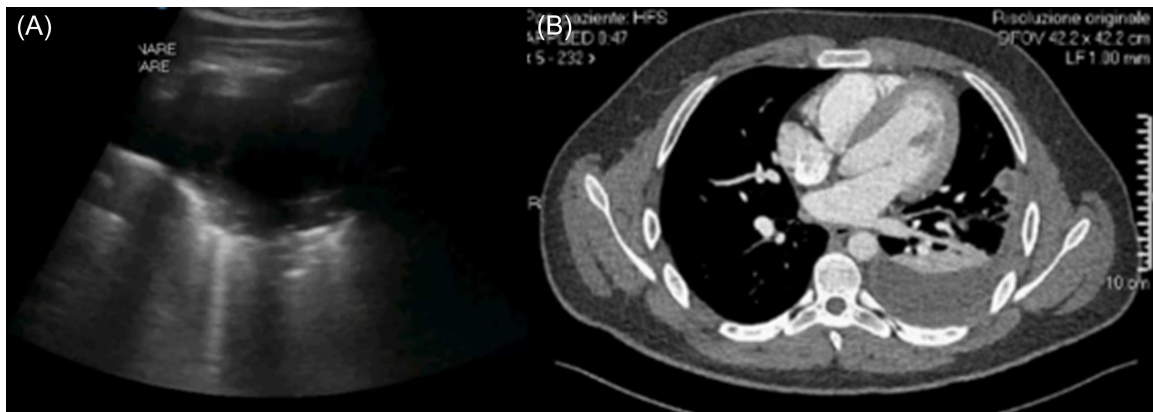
Third case report. (A) POCLUS with convex probe in longitudinal position showing presence of corpuscular liquid collection with a diameter of 11 cm in length and 4 cm in depth on the left posterior mid-basal area, with atelectatic underlying lung with air bronchogram. (B) Chest CT without and with contrast showing increased sac pleural effusion with suprahidric density for corpuscular quota in the context, located on the left in the posterior recess, with maximum extension at the VII posterior intercostal space with longitudinal diameter of 20 cm, transversal diameter of 8.4 cm and antero-posterior diameter of 3.8 cm.
